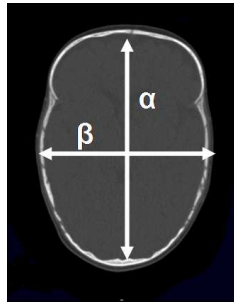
The scaphocephaly severity index is computed as the head width to length ratio β/α as measured on a CT plane extracted from skull shape imaging.
